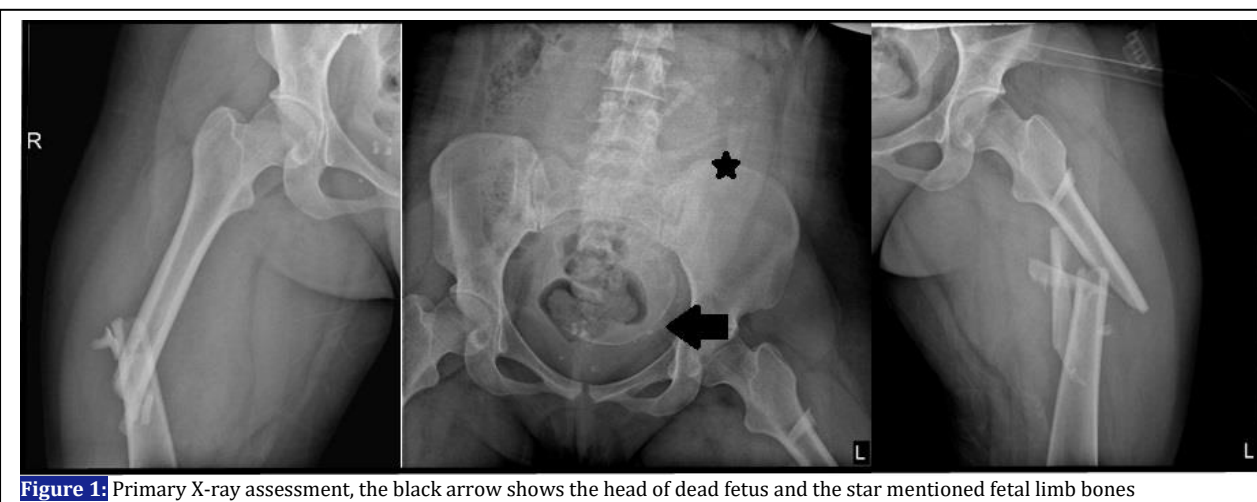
Primary X-ray assessment, the black arrow shows the head of dead fetus and the star mentioned fetal limb bones
